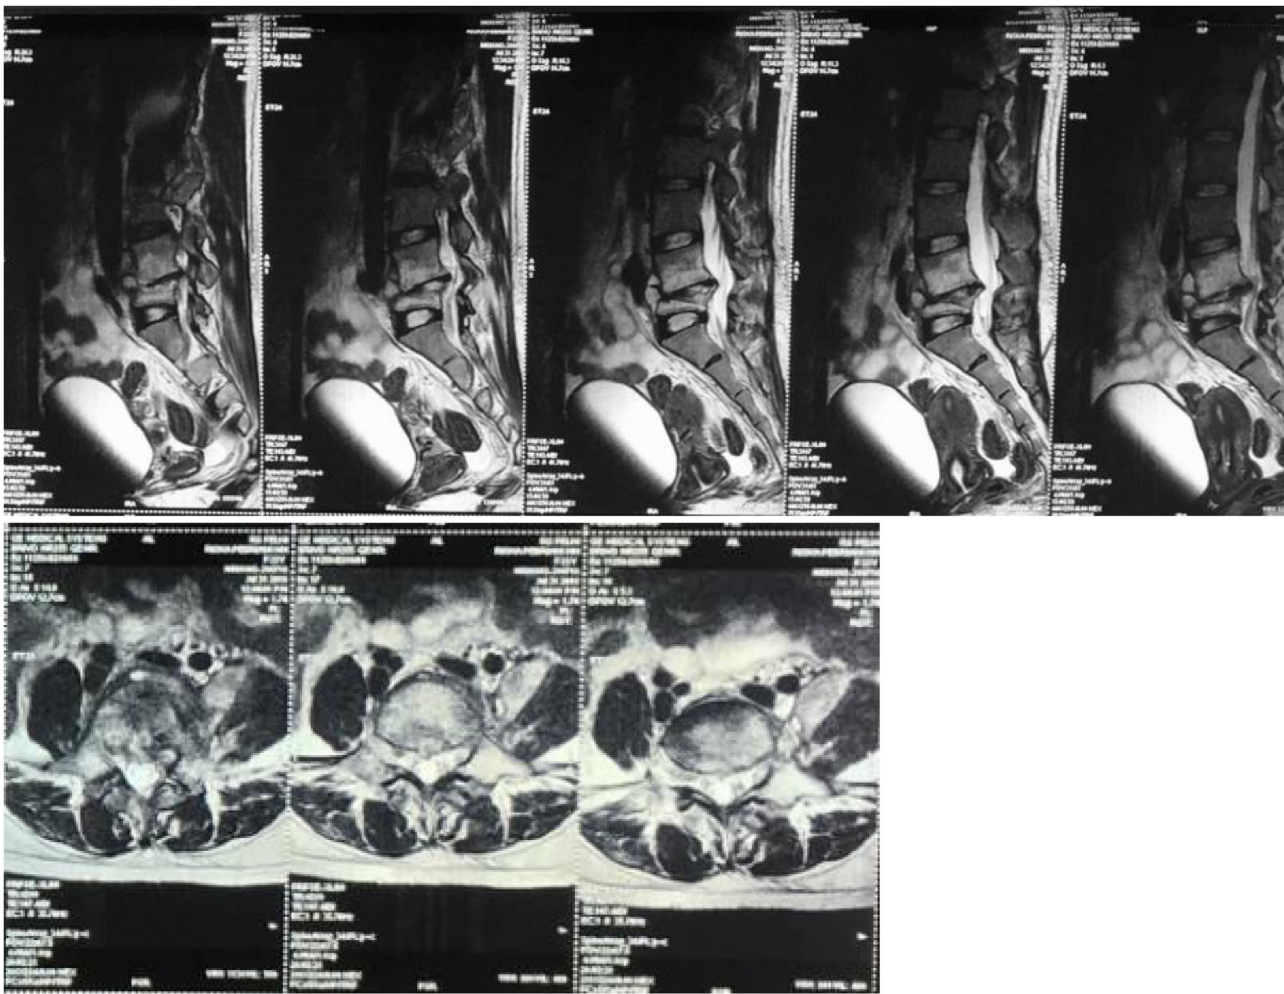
Lumbosacral MRI. The findings were loss of lumbar lordosis, corpus destruction of L5, decrease intervertebral body height at L4-L5 and L5-S1, protrusion of L4-L5 intervertebral disc into the spinal cord, and paraspinal abscess.
